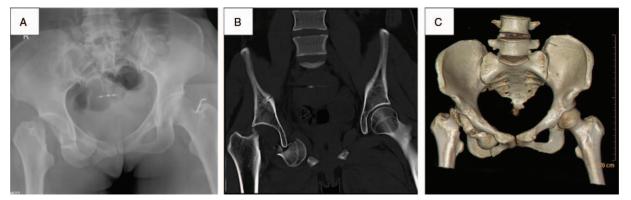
X-ray examination (A), CT scanning (B), and 3D reconstruction (C) of the pelvis and femurs indicating obturator dislocation of the femoral head combined with ipsilateral femoral neck fracture and public fracture. CT = computed tomography.
